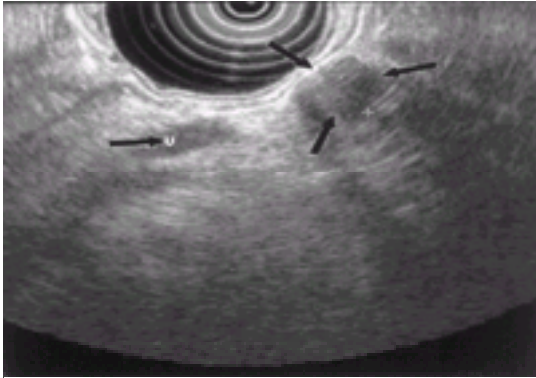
Endoscopic ultrasonography of insulinoma. The endoscope is passed into the stomach and the balloon inflated with saline. A 2-cm insulinoma is identified in the tail of the pancreas (three arrows). Notice how the tumor is sonolucent compared to the more echo-dense pancreas. The tumor is near the splenic vein (v, single arrow), which courses through the body and tail of the pancreas.
